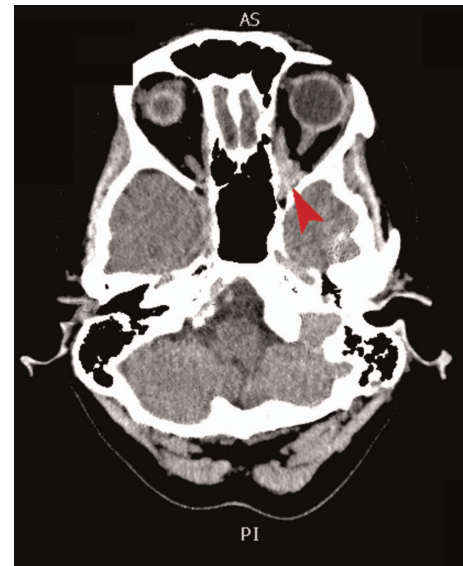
CT scan of head, which was initially reported as normal. On closer inspection, there is a left orbital apex anomaly.
